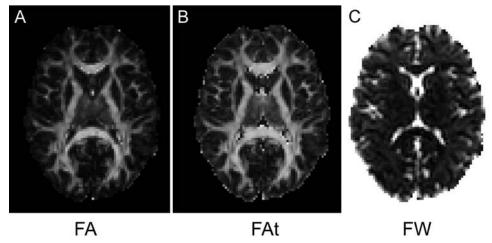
Diffusion MRI contrasts. A: Fractional anisotropy is a contrast sensitive to elongated shapes, such as those found in myelinated axons. It provides a clear contrast between white matter and gray matter. B: Using the free-water imaging method provides an FAt map, which is an FA map that is corrected for CSF and free-water contaminations. The FAt map provides a similar contrast to the FA map, except that it is brighter in areas next to the ventricles and around the brain parenchyma, where partial volume with CSF occurs. C: The free-water measure (labeled as FW) provides a contrast that measures the fractional volume of free-water, which is expected to be high in CSF-filled spaces and low (but not necessarily 0) in areas of condensed white matter fibers.
